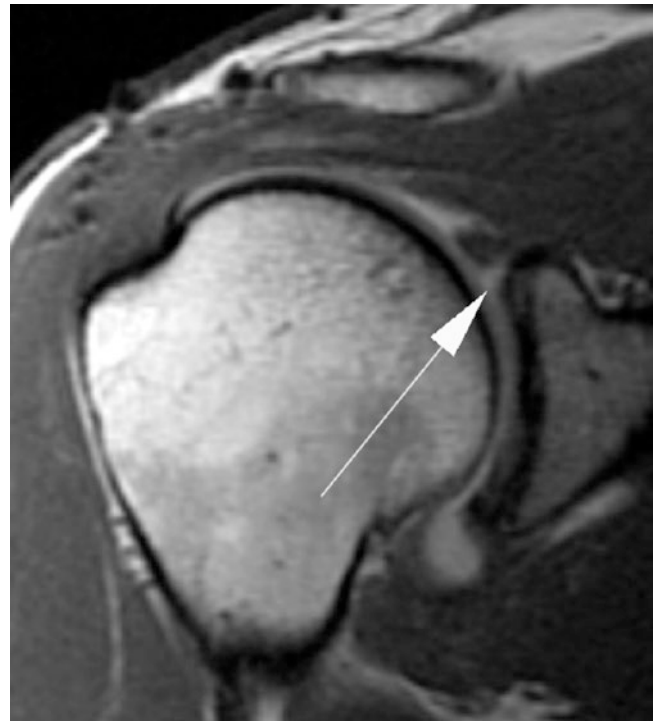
Coronal oblique T1-weighted image from direct MR arthrogram shows a normal small smooth cleft (arrow) partially undercutting the superior labrum after SLAP repair. The labral repair was intact at second look arthroscopy
